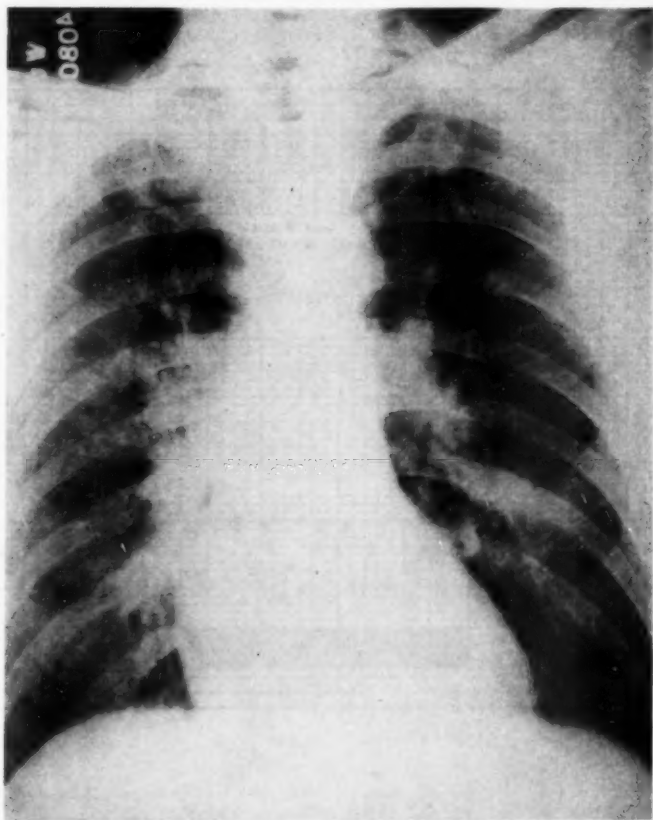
Case 4. Admission chest roentgenogram. There is prominence of both hilar areas and non-confluent, patchy infiltration in mid left lung and right apex and near each hilum.
